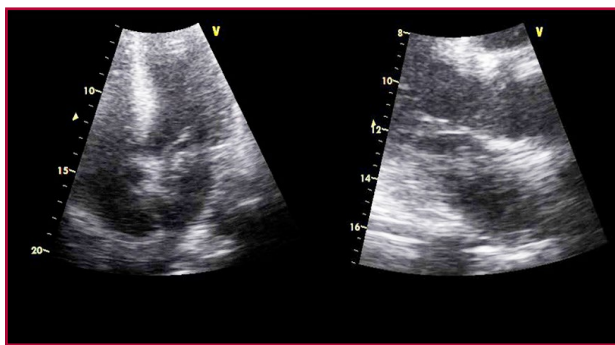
Doppler echocardiography image consistent with thrombus in transit
